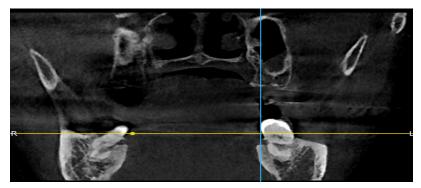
cone beam scan (CBCT) with sagittal view before treatment
